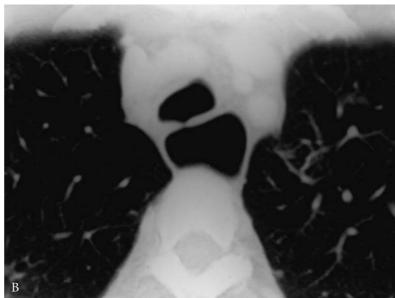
H-type tracheoesophageal fistula in a 49-year-old woman. A, Fistula demonstrated (arrow) by barium contrast swallow. The trachea is clearly outlined. B, Computed tomography scan showing the small fistula. The fistula was divided and repaired easily through a low collar incision. Also, see Figure 6-21B. (Courtesy of Dr. Hon Chi Suen.)
